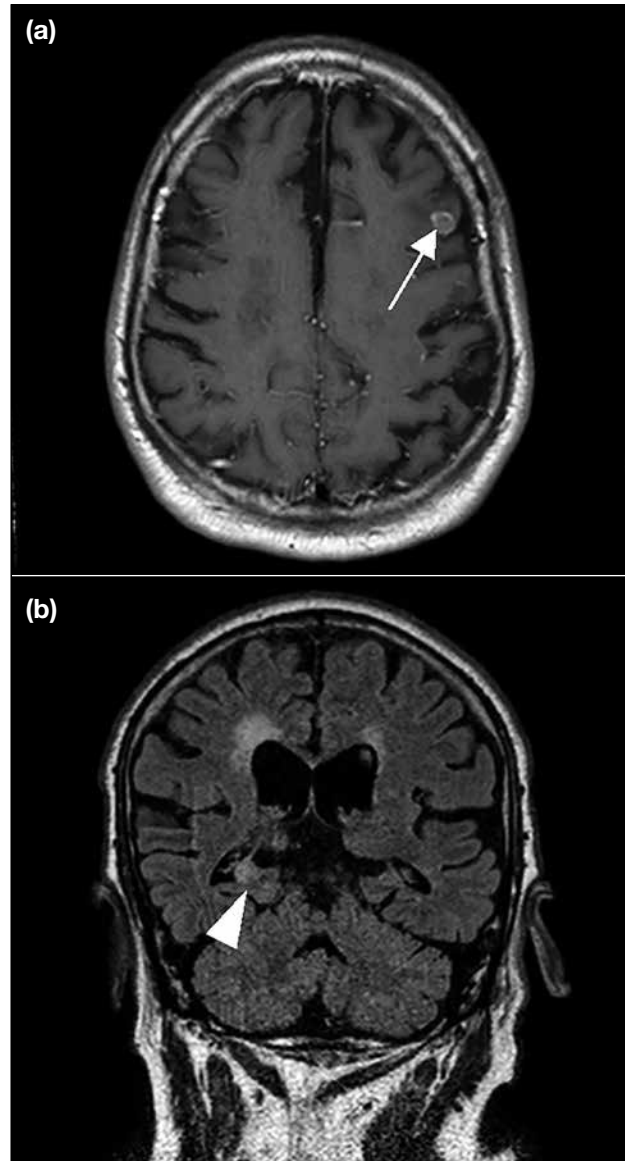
Magnetic resonance imaging of the brain 4 days after admission. (a) T1-weighted image with contrast demonstrating an enhancing left frontal lobe lesion likely representing a tumour (arrow). (b) Coronal fluid-attenuated inversion recovery image demonstrating slightly increased signal at the right hippocampus (arrowhead) suspected to be related to convulsion.
